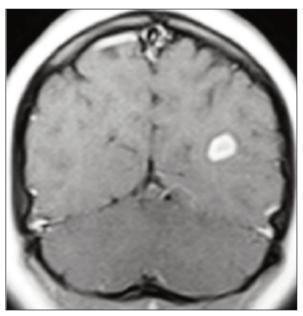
Coronal contrast-enhanced T1-weighted image shows an enhancing plaque in the left occipital white matter.
